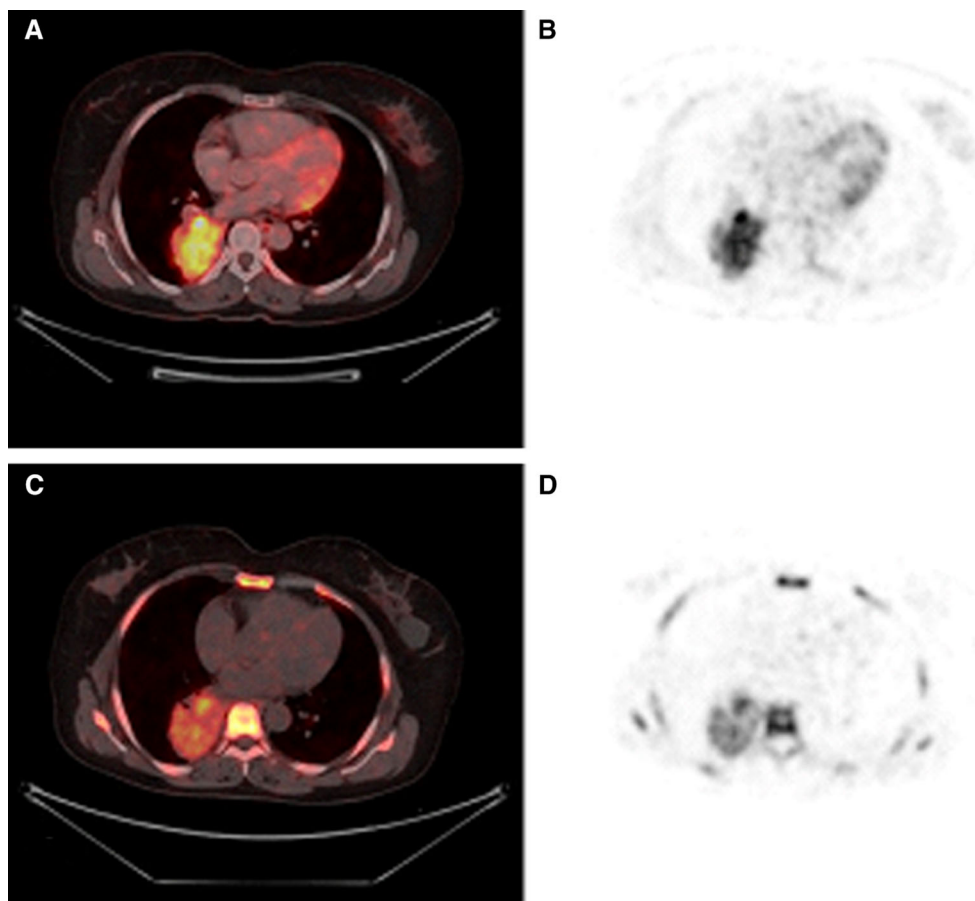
Transaxial fused ^{18}F -FDG PET/CT (a), FDG PET only (b), fused ^{18}F -FLT PET/CT (c), FLT PET only (d) showing increased tracer uptake in primary site of a NSCLC patient
